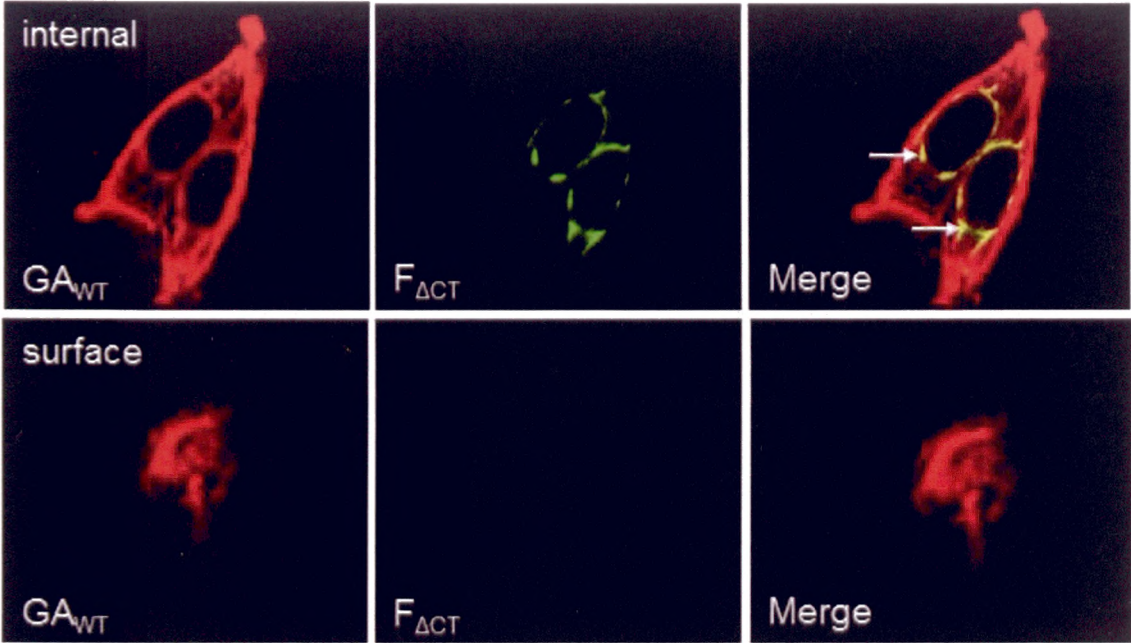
HEp-2 cells expressing wild-type GA_{WT} protein and cytoplasmic tail-region deleted $F_{\Delta CT}$ protein as seen by a 100X confocal objective. F protein is labeled with green dye FITC. GA protein is labeled with red dye Alexa Fluor 555. When both colours are combined (Merge), the yellow coloured areas represent co-localisation of F and GA proteins in the cells. The internal (top row) and surface (bottom row) views of the cells are shown. Arrows indicate the areas of co-localisation around the nucleus.
